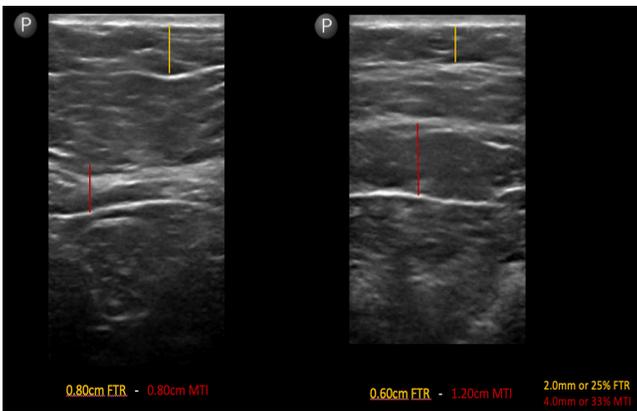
This was a 27-year-old Latino male who received six treatments on his abdomen and flanks. The left ultrasound shows baseline and the right ultrasound shows 12 weeks follow-up of the treated abdomen. He had 33% Muscle Thickness Increment and 25% Fat Thickness Reduction.
